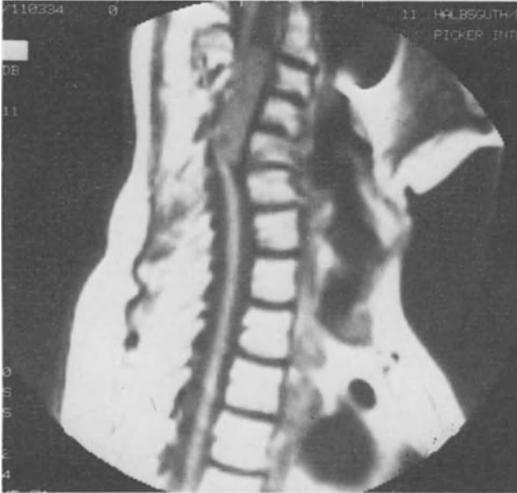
MRI: intradurally located tumor at the level of C3-C5. Pronounced malposition of the cervical spine
